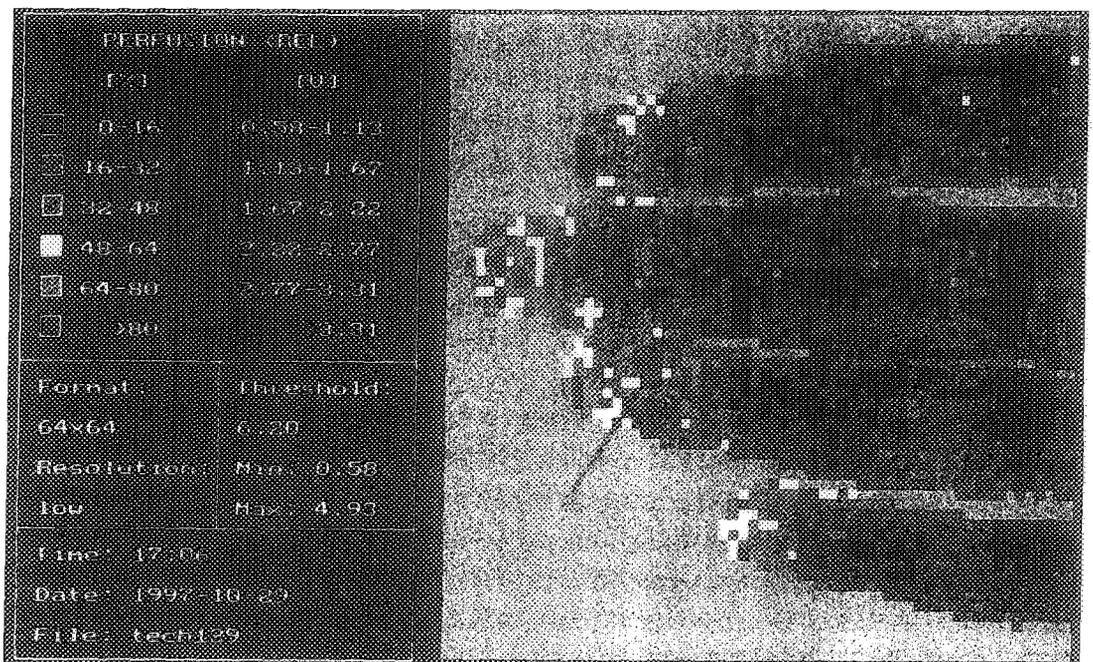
Laser Doppler Images Obtained by the PIM 1.0
